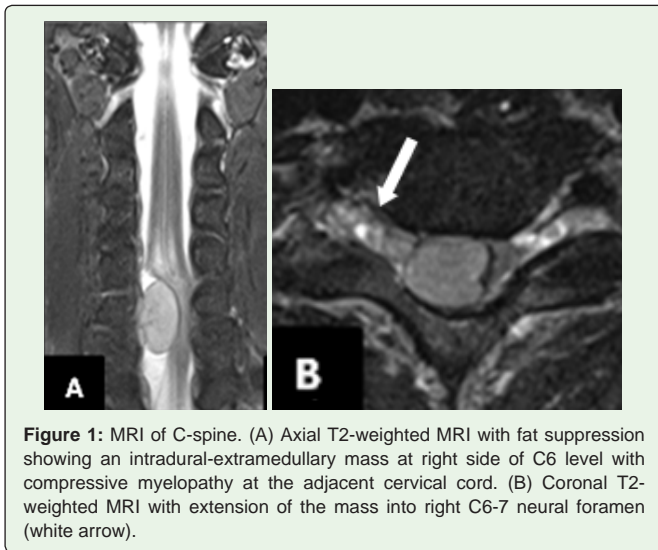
MRI of C-spine. (A) Axial T2-weighted MRI with fat suppression showing an intradural-extramedullary mass at right side of C6 level with compressive myelopathy at the adjacent cervical cord. (B) Coronal T2-weighted MRI with extension of the mass into right C6-7 neural foramen (white arrow).
